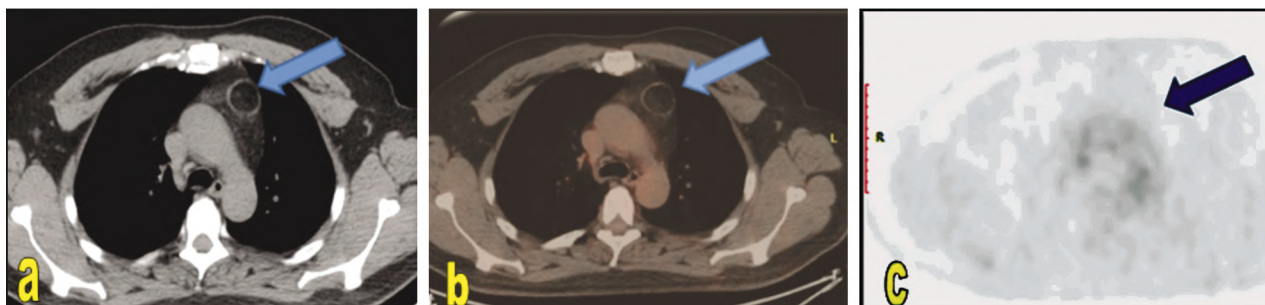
PET CT study for a male patient 48 year old presented with chest tightness. Axial CT Chest with fused PET images (A,B,C) showing left anterior mediastinal lesion with internal calcification & fatty areas seen within, No FDG Uptake (Arrowed). PET/CT Diagnosis: Benign looking lesion, most likely teratoma. Pathology revealed: Mature Benign Teratoma.
